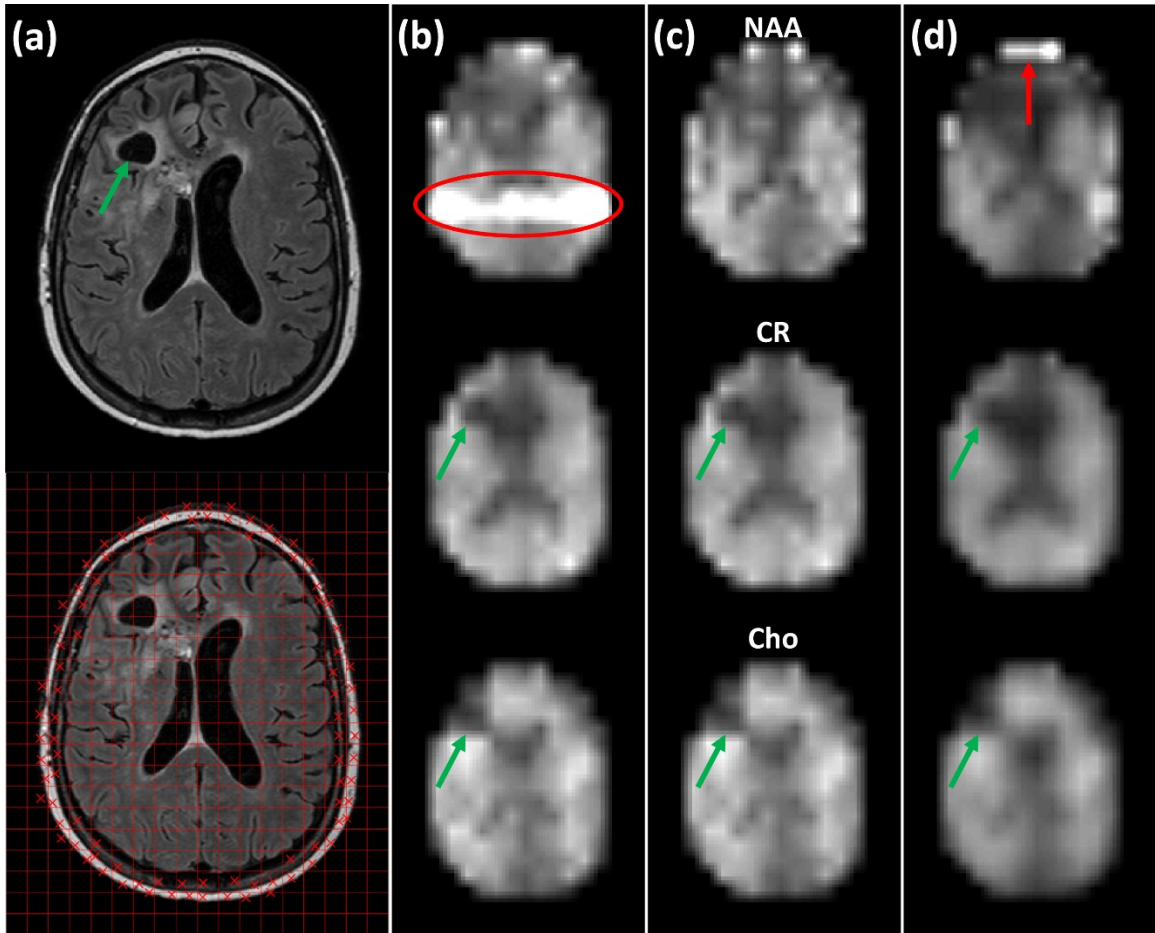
(a) FLAIR image from a patient with a resected glioblastoma, and overlaid with optimized PANGS scalp coordinates (x, bottom). Parts (b-d) are corresponding NAA, CR and Cho metabolite maps (top to bottom) reconstructed from: (b) CSI without a cosine filter, (c) PANGS and (d) CSI with a cosine filter. Image contrast thresholds are set identically. Regions outside the brain (including scalp) are masked from these maps. Hyper-intense lipid artifacts are indicated in red in (b) and (d). Green arrows indicate the surgical resection.
